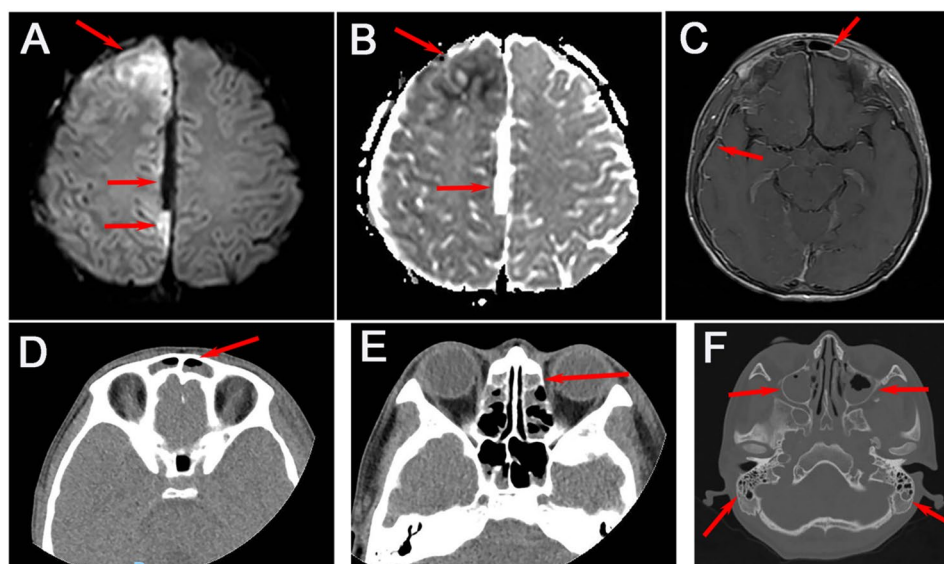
The imaging manifestations of brain and ear/nose on admission. A (DWI) and B (ADC) showed restricted diffusion in the brain parenchyma of the right frontal pole, subdural effusion in the right frontal part and right side of cerebral falx, and subdural empyema in the right side of posterior falx (posterior arrow). C (enhanced T1) showed pachymeningeal enhancement of the right cerebral hemisphere and frontal sinusitis. D, E, and F showed frontal sinusitis, ethmoidal sinusitis, sphenoidal sinusitis, and mild mastoiditis by CT
